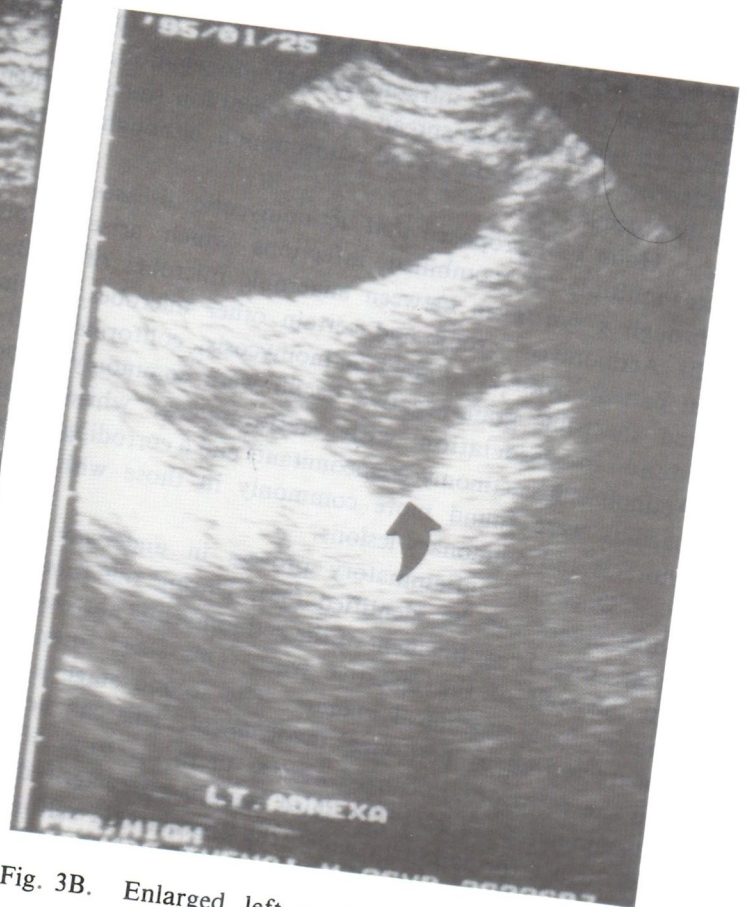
Enlarged left ovary with solid lesion at posterior part, at sonography
